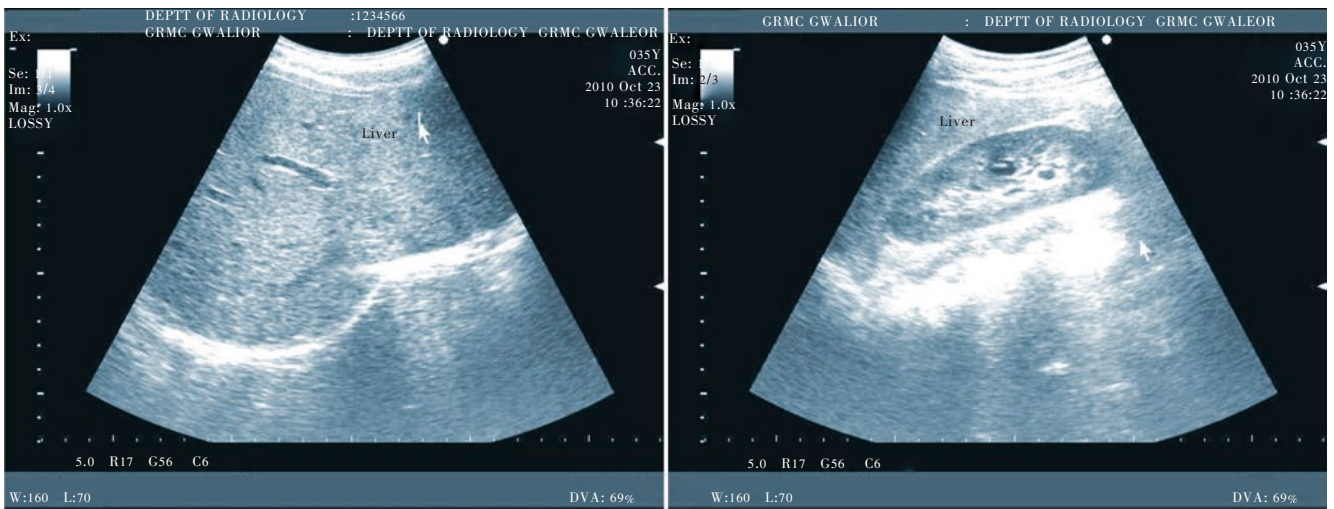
Sonogram showing example without fatty liver (normal patient).
